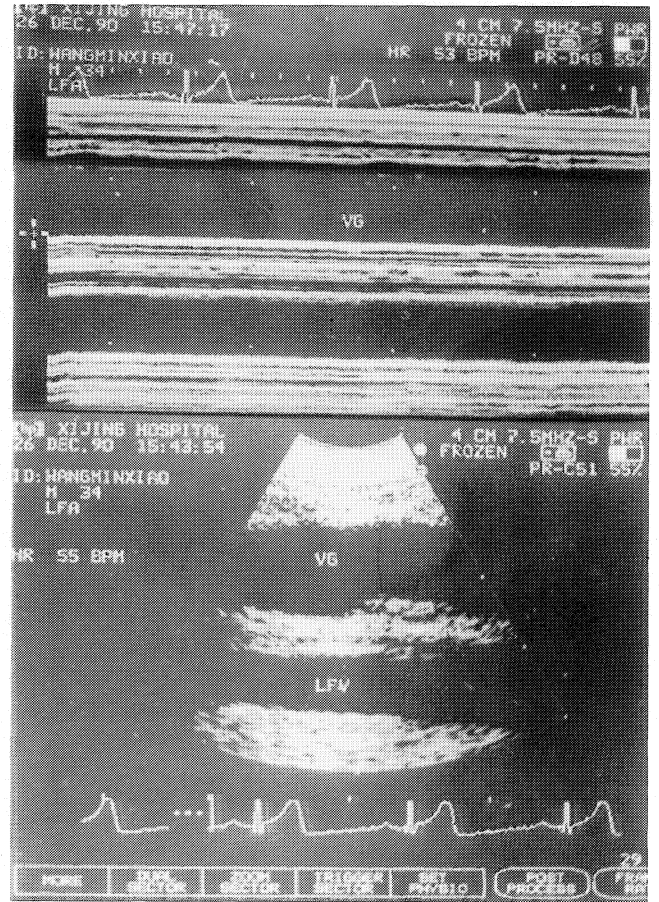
Doppler-ultrasonic imaging shows patent graft.
